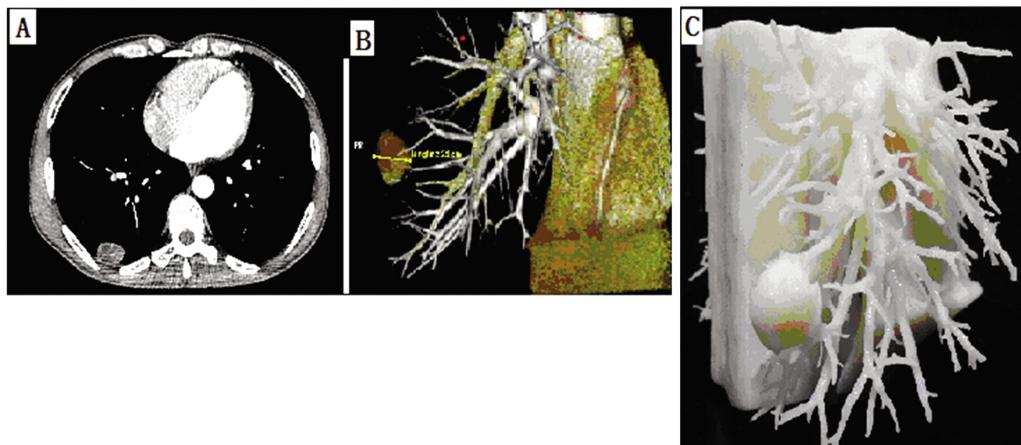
A: CT 图像; B: 3DI 模型; C: 3DP 模型
